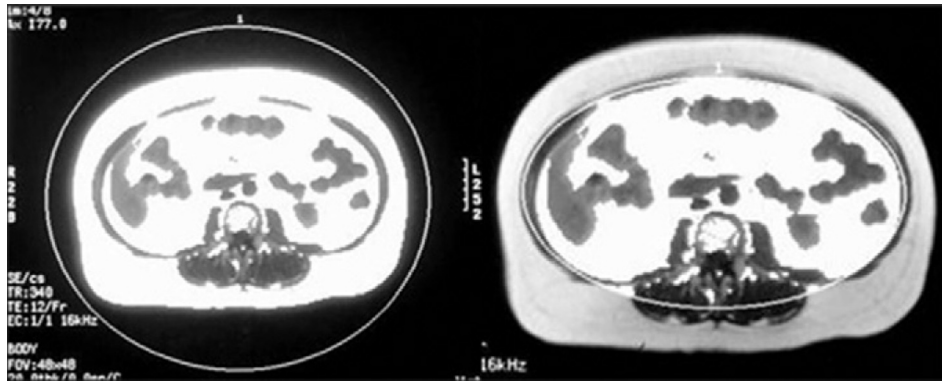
Magnetic resonance imaging showing different adipose compartments. The outer elliptic ring signifies both subcutaneous and intra-abdominal fat. The inner elliptic ring signifies intra-abdominal fat.
